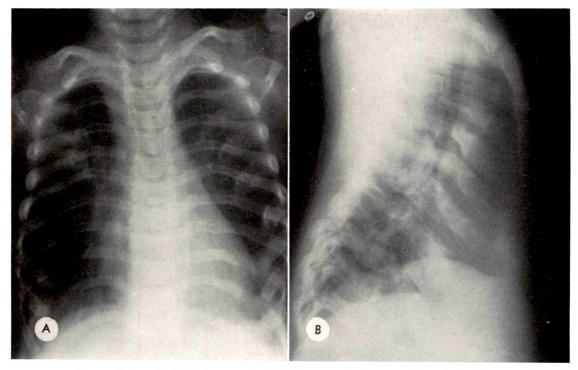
Case v. (A) Posteroanterior and (B) lateral roentgenograms of the chest.
